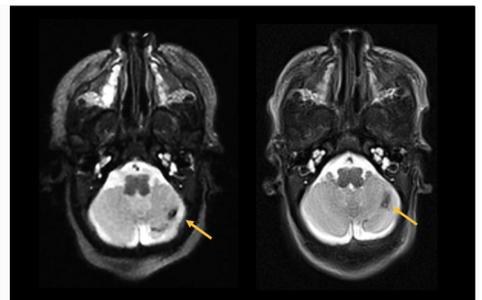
T1 and T2 weighted images from Embrace 1T In-NICU MRI & 3T Conventional MRI – History: Term infant with HIE, therapeutic hypothermia x 72 hours for severe encephalopathy. Incidental finding of polymicrogyria.
